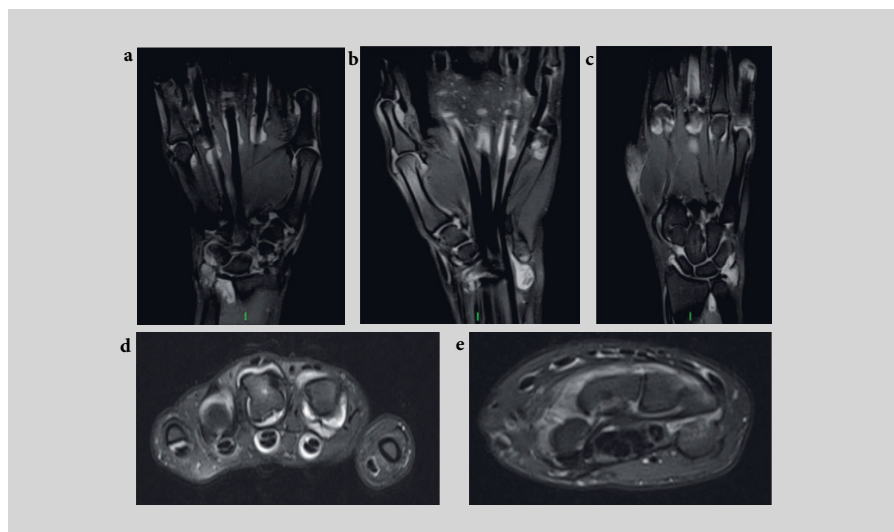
Coronal and axial inversion recovery magnetic resonance images (MRI) of bilateral hands. This MRI demonstrates synovitis and effusion of carpal and metacarpophalangeal joints (a–c), as well as tenosynovitis of flexor tendons (d, e). The MRI gives us a more complete picture of the rheumatoid process by revealing the degree of inflammation present in the tendon compartments and surrounding structures. Although the clinician sees the swollen hand and the patient feels pain diffusely in the hand, these images demonstrate the extent of involvement of both joints as well as tenosynovial structures throughout the hand and wrist.
